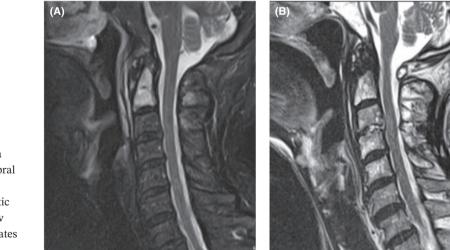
(A) Short tau inversion recovery (STIR) MRI shows a hyperintense signal at the C1-C2 vertebral bodies, suggesting the presence of inflammation. (B) T2-weighted magnetic resonance imaging (MRI) reveals a new deformity at the C3-C4 vertebral endplates and a hyperintense signal at C3/C4 intervertebral disks
